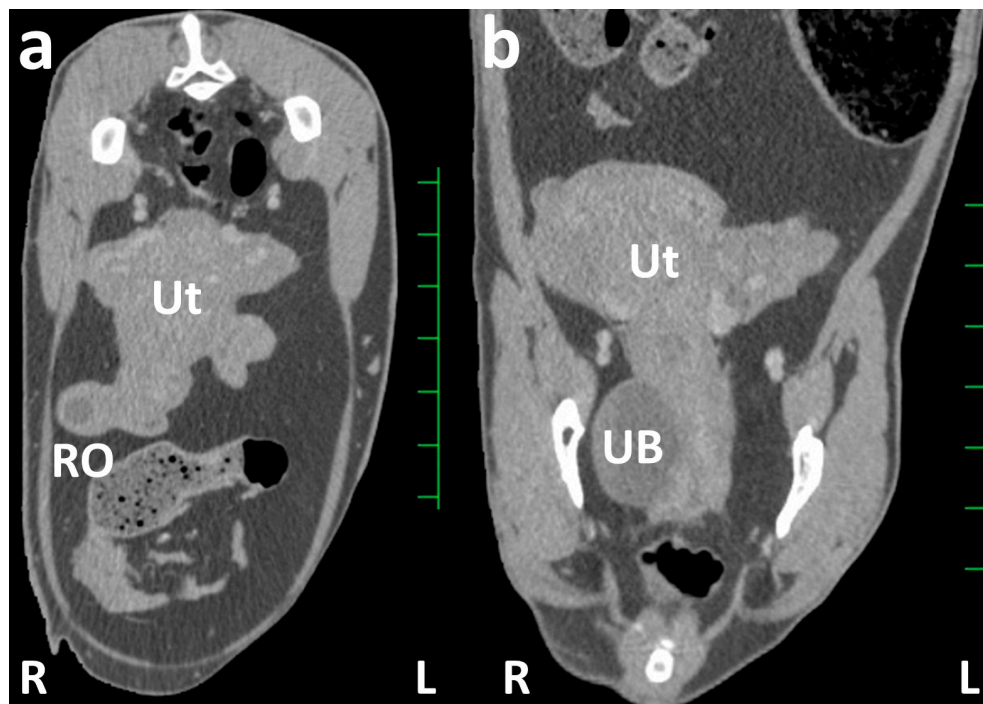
Transverse (a) and dorsal (b) contrast computed tomography images of the caudal abdomen. (a) The right uterine horn is shown as an enlarged, round structure, larger than that of the left uterine horn. The homogeneously contrast-enhanced structure represents the enlarged uterus (Ut), wherein the uterine lumen is unclear. The contrast-enhanced ball-like structure of the right ovary (RO) includes a round cystic structure with weak contrast enhancement. (b) The uterus (Ut) is represented as the enlarged uterine cervix running along the urinary bladder (UB) within the pelvic cavity, and the uterine horns extend to the location approximately 4 cm cranially compared with the pelvis. Scale = 25 mm.
